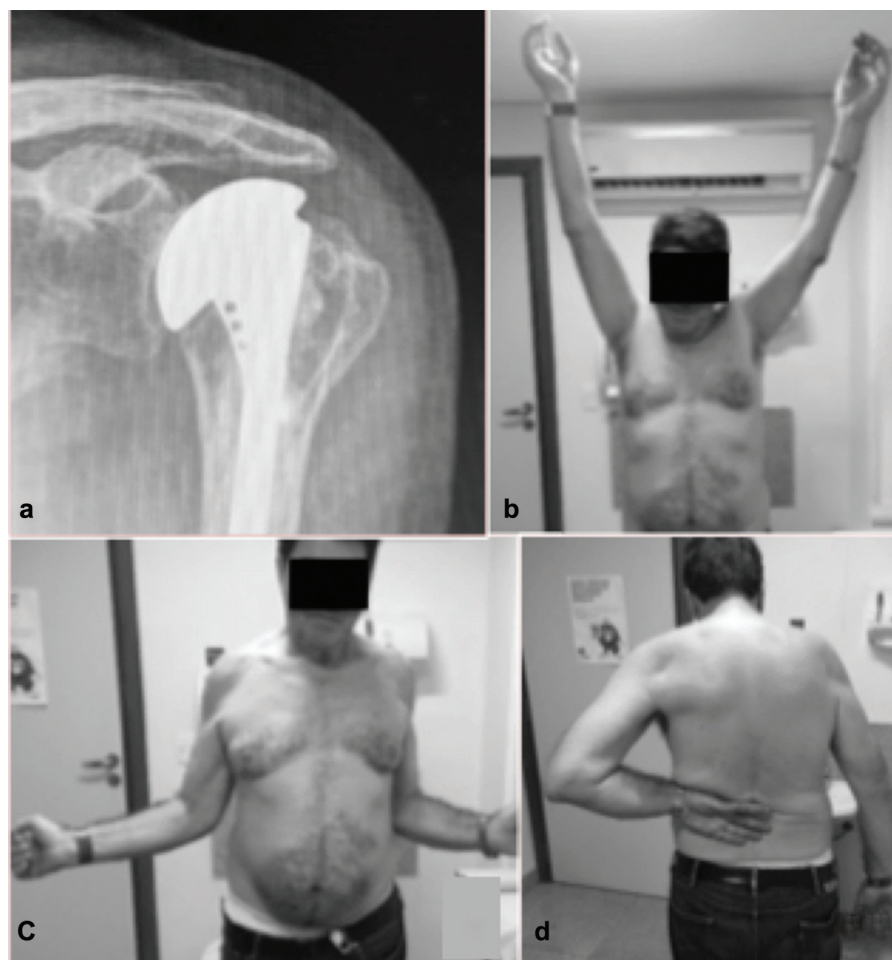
Patient at 13 postoperative years of partial arthroplasty for posttraumatic osteonecrosis. (a) radiographic examination shows decreased glenohumeral joint space and erosion of glenoid cavity. Patient with 34 points in the University of California, Los Angeles (UCLA) classification, with good joint mobility: (b) elevation, (c) lateral rotation and (d) medial.
